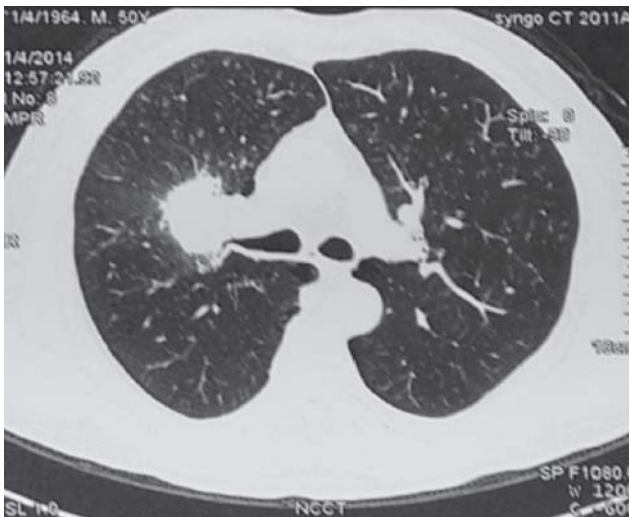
Computed tomography of chest showing mass at the level of tracheal bifurcation.
